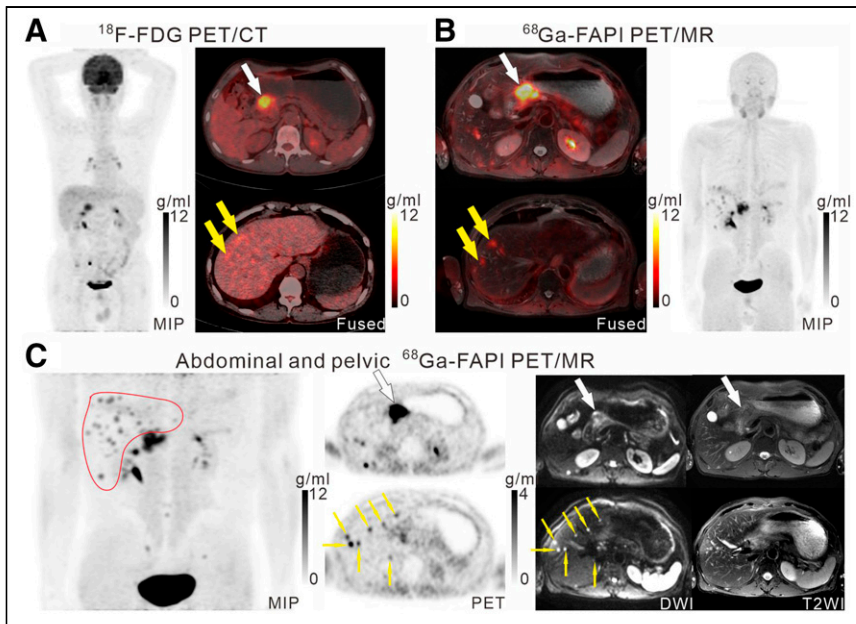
A 61-y-old man (patient 7) with moderately differentiated gastric adenocarcinoma. In addition to the primary tumor (A, white arrow, $SUV_{max} = 11.0$), 2 foci of elevated activity in the liver were noted on the ^{18}F -FDG PET/CT images (A, yellow arrows, $SUV_{max} = 5.8$). On the ^{68}Ga -FAPI PET/MR images, the primary tumor had more intense uptake (B and C, white arrows, $SUV_{max} = 14.2$), and the 2 hepatic lesions had more prominent ^{68}Ga -FAPI accumulation (B, yellow arrows, $SUV_{max} = 7.6$). Additionally, multiple foci of increased ^{68}Ga -FAPI activity were also revealed in the liver (C, red outline, yellow arrows), which corresponded to multiple high signals on DWI (yellow arrows), suggesting multiple hepatic metastases.
